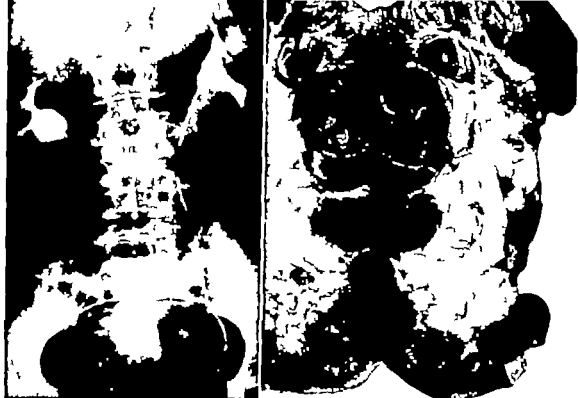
Roentgenogram with retrograde pyelography. Note distortion of superior calyx of left kidney. The patient had hematuria and a differential diagnosis between cyst and tumor could not be made. (W U neg. 49-7135)
